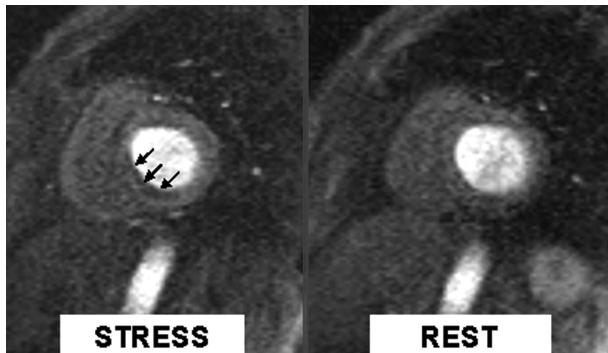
Adenosine stress perfusion base-ventricle cardiac magnetic resonance imaging (left) and rest perfusion base-ventricle cardiac magnetic resonance imaging (right). Arrows indicate areas of reduced myocardial perfusion, worsened during stress (left).
